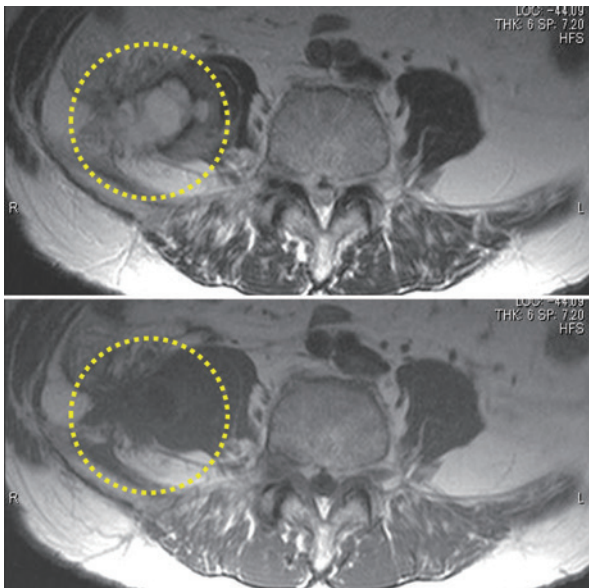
MRI on the second hospital day showing a right iliopsoas mass with central fluid collection with high intensity around mass in T2 images (yellow dotted circles)
